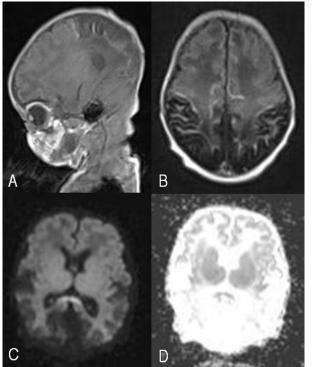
T1WI – parasagittal (A), axial (B), DWI (C) and ADC (D) showing cortical laminar necrosis with restricted diffusion in splenium with low ADC values. Cortical laminar necrosis shows gyriform hyperintensity on T1WI
